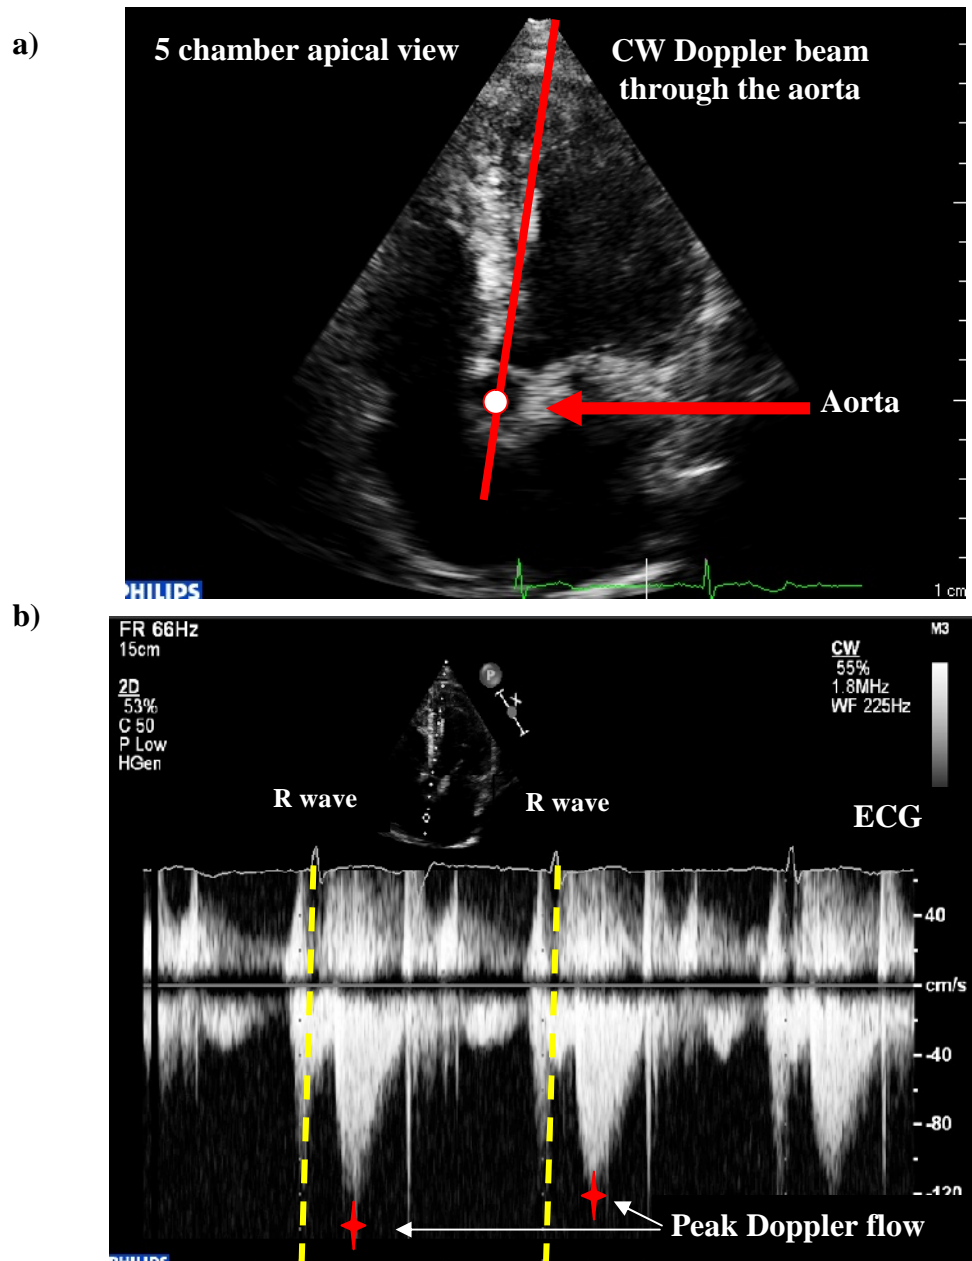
An example of aortic flow measurement using continuous wave Doppler in the 5 chamber apical view shown in a). The aortic flow trace recorded is shown underneath in b). The time interval was measured between the R of the QRS complex (represented as the dashed yellow line) and peak aortic flow, (shown by the red crosses (†)). Peak Aortic flow was used as a surrogate marker for reflected wave arrival.
